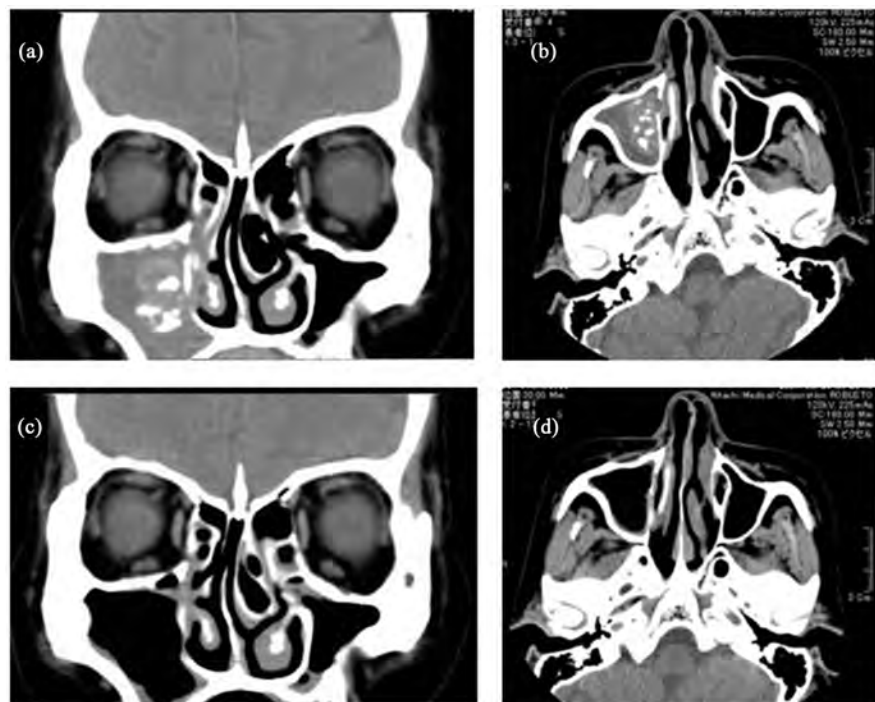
CT examination of a case where the combined method was utilized: Figure 3(a) and Figure 3(b) show soft tissue attenuation with a high-density lesion in the right maxillary sinus. Figure 3(c) and Figure 3(d) show the post-operative CT after ESS with both the middle and the inferior meatal antrostomy.
